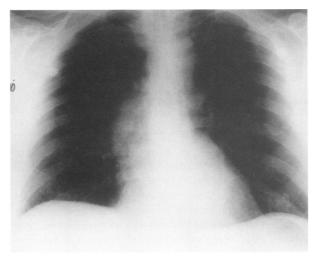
Chest radiography reveals elongation and tortuosity of the ascending aorta.
